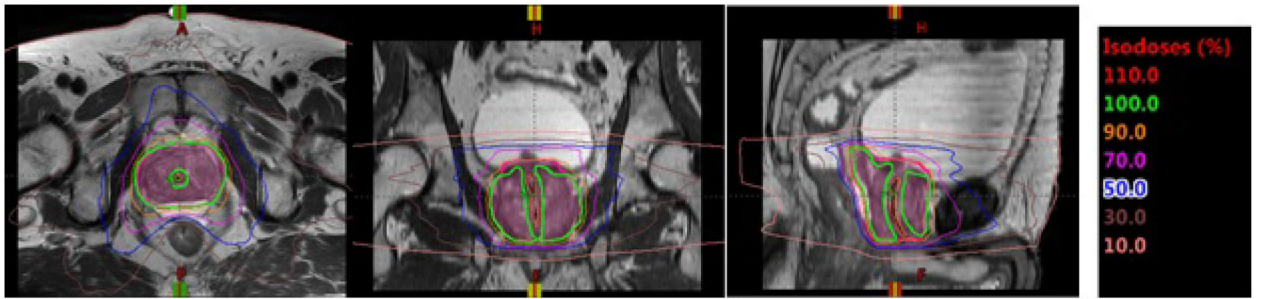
Isodose line displayed on a T2-weighted MR image for a patient planned for five-fraction stereotactic body radiation therapy (SBRT). Dose around the urethra was reduced to meet institutional guidelines for urethra.
